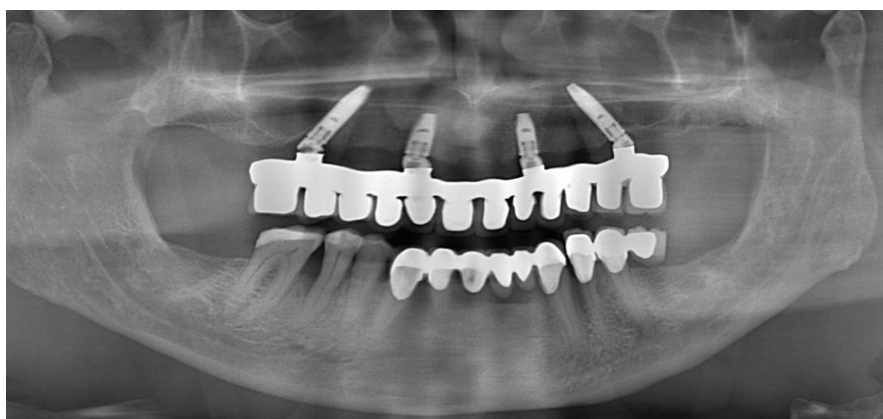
Representative post-loading of orthopantomography of the same patient rehabilitated with a maxillary All-on-four.
